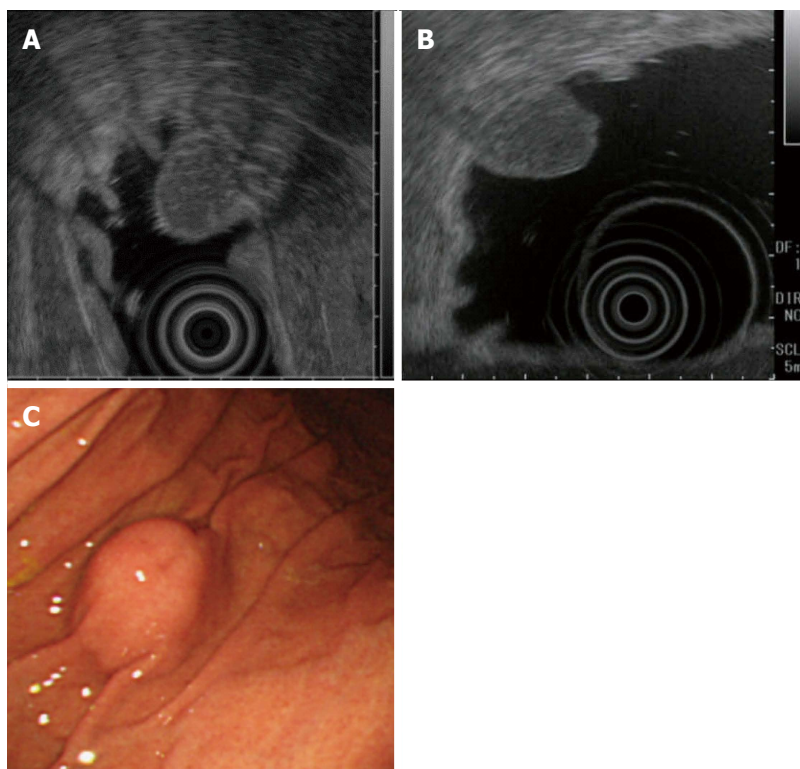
Ectopic pancreas. A: EUS finding at baseline, tumor diameter is 15.5 mm; B: EUS finding at five years later; C: Endoscopic finding. Ectopic pancreas has no change in five years. EUS: Endoscopic ultrasound.
